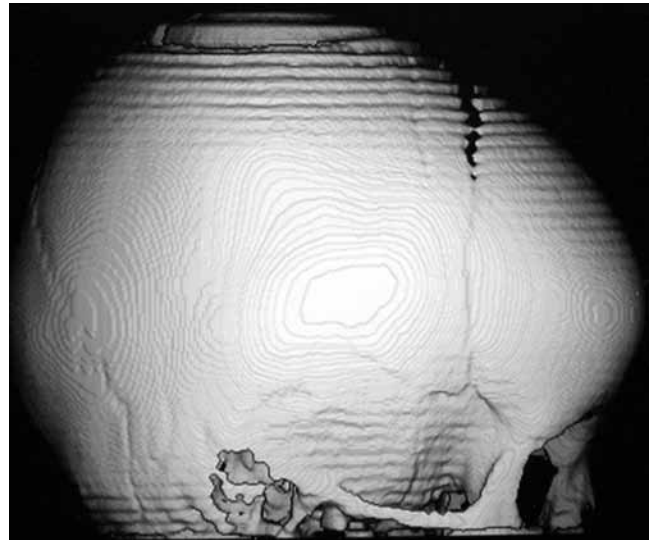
Lateral view of 3D CT reconstruction of plagiocephalic skull.
